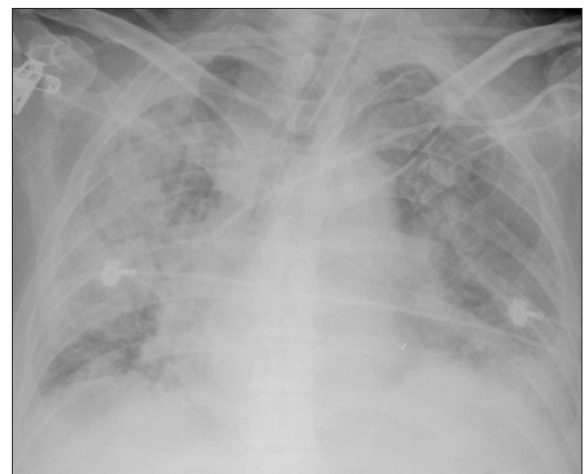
Chest X-ray on day 35 after first nivolumab revealed a bilateral diffuse alveolar pattern and immune-related pneumonitis was diagnosed; invasive ventilation was applied for deteriorating oxygenation
